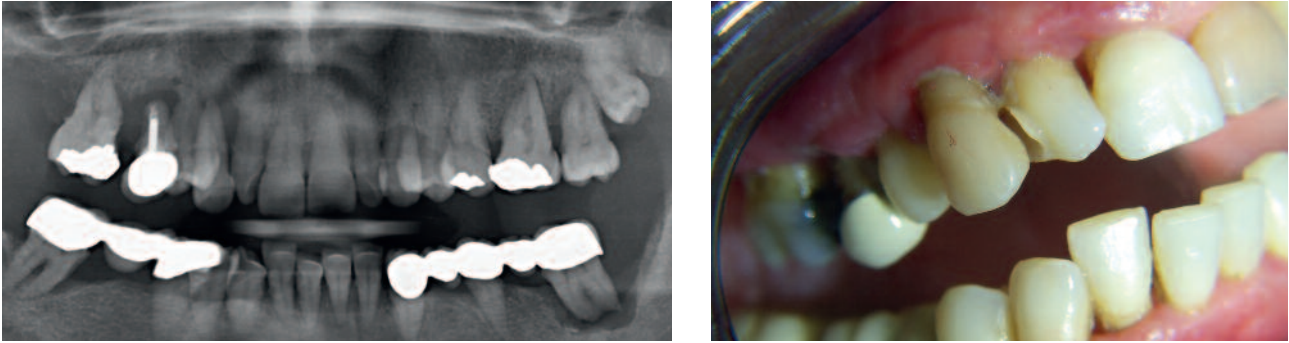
X-ray control after five months.
